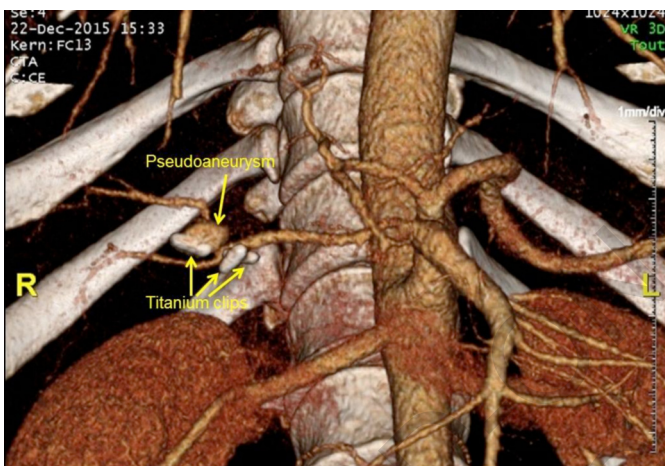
Abdominal CT reconstruction showing a pseudoaneurysm of the right hepatic artery.
